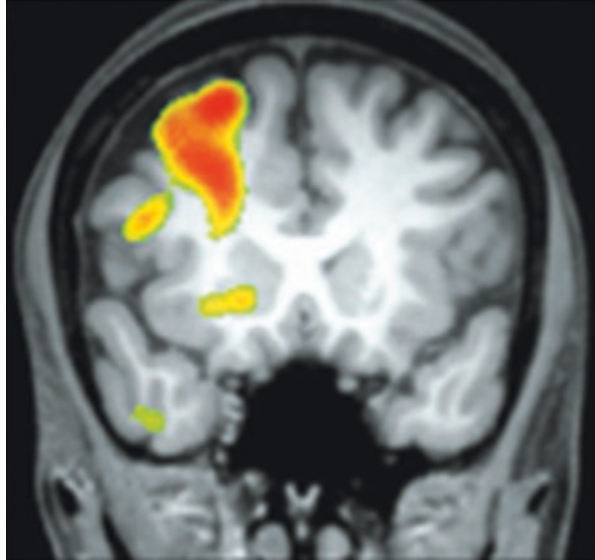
Coronal view SPECT showed the area of hyperperfusion. This area was included in the resection
